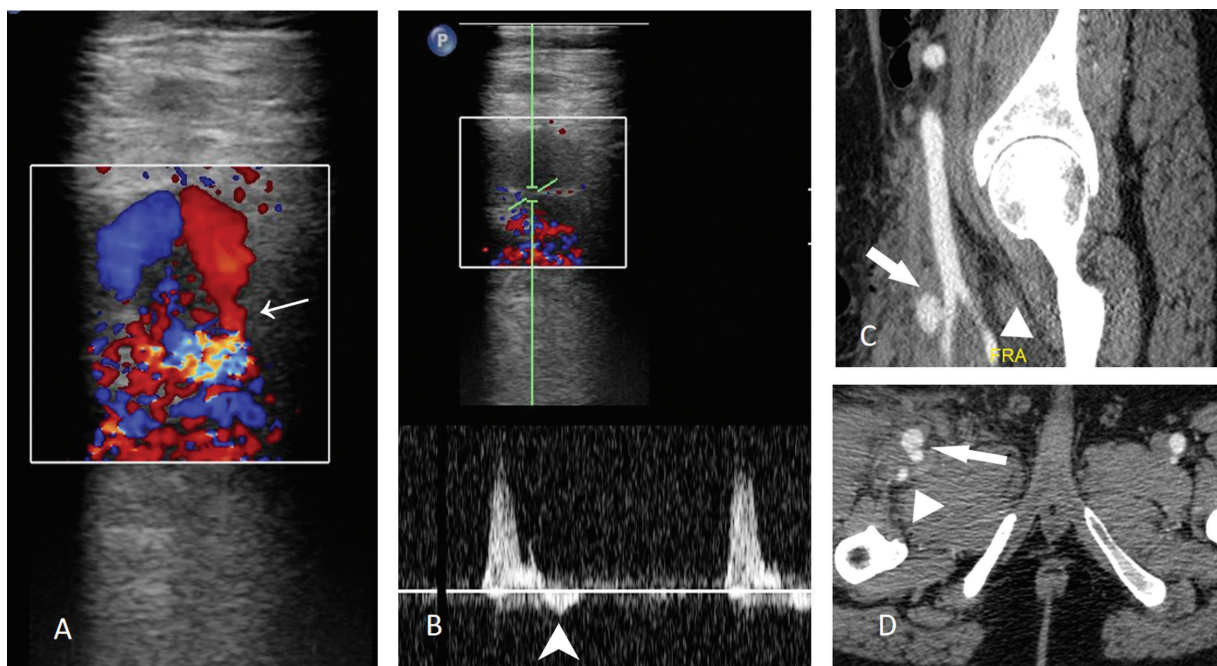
Pseudoaneurysm (PSA) in a patient seen arising from superficial femoral artery (SFA) due to low puncture. Color Doppler (A) shows yin yang type of flow in pseudoaneurysm with a narrow neck (arrow) and on spectral trace Doppler (B) at the neck of aneurysm shows to and fro wave pattern (arrow in B). Contrast-enhanced computed tomographic images (C and D) show PSA with a narrow neck arising from SFA (bold white arrow) with normal profunda femoral artery. This patient underwent successful ultrasound-guided compression.
